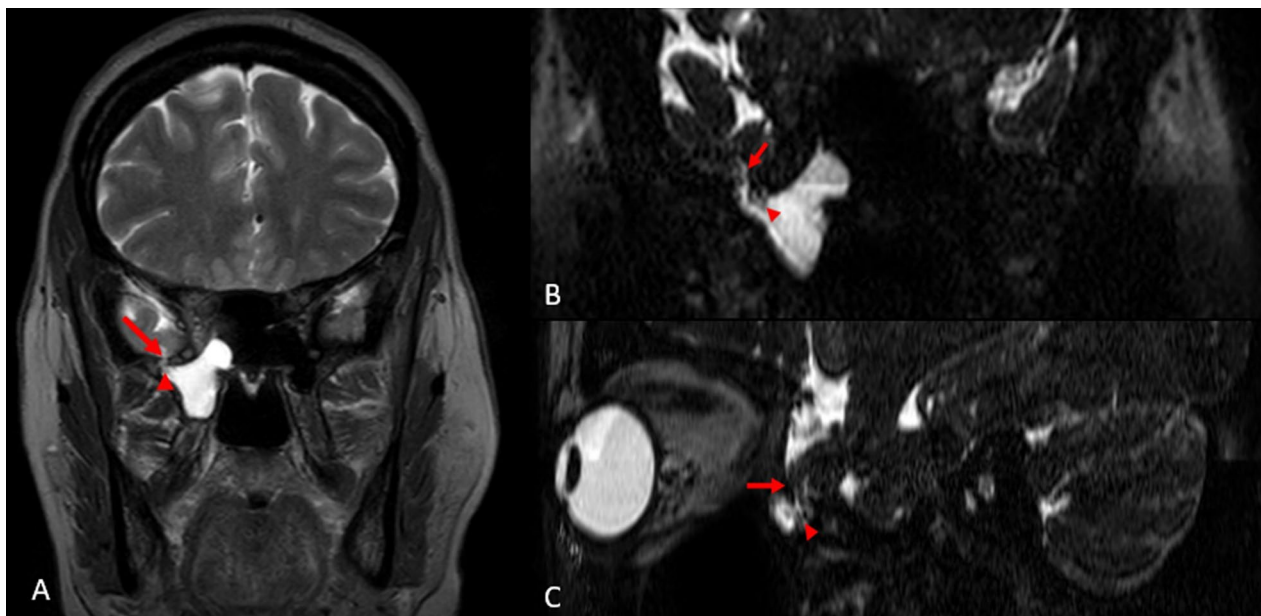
A T2W image coronal section showing the defect in the right greater wing of sphenoid bone (red arrow) with predominant downward herniation of meninges and adjacent minimal brain parenchyma (red arrowhead). MRI brain CISS sequence B Coronal and C sagittal sections showing the defect in the right greater wing of sphenoid bone (red arrow) with downward herniation of meninges and adjacent minimal brain parenchyma (red arrowhead)
